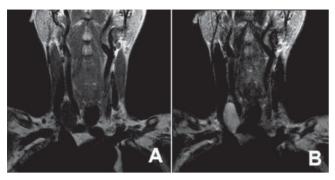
MR imaging: Coronal T1-weighted (500/15) image (A) and coronal T2-weighted (5000/131) image (B) show an ovoid mass in right carotid sheath, between internal jugular vein and carotid artery. NB dishomogeneous high signal intensity in T2-weighted sequence.
